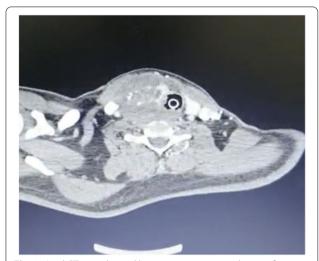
Axial CT scan showed heterogenous mass with area of calcification arise from right thyroid lobe
